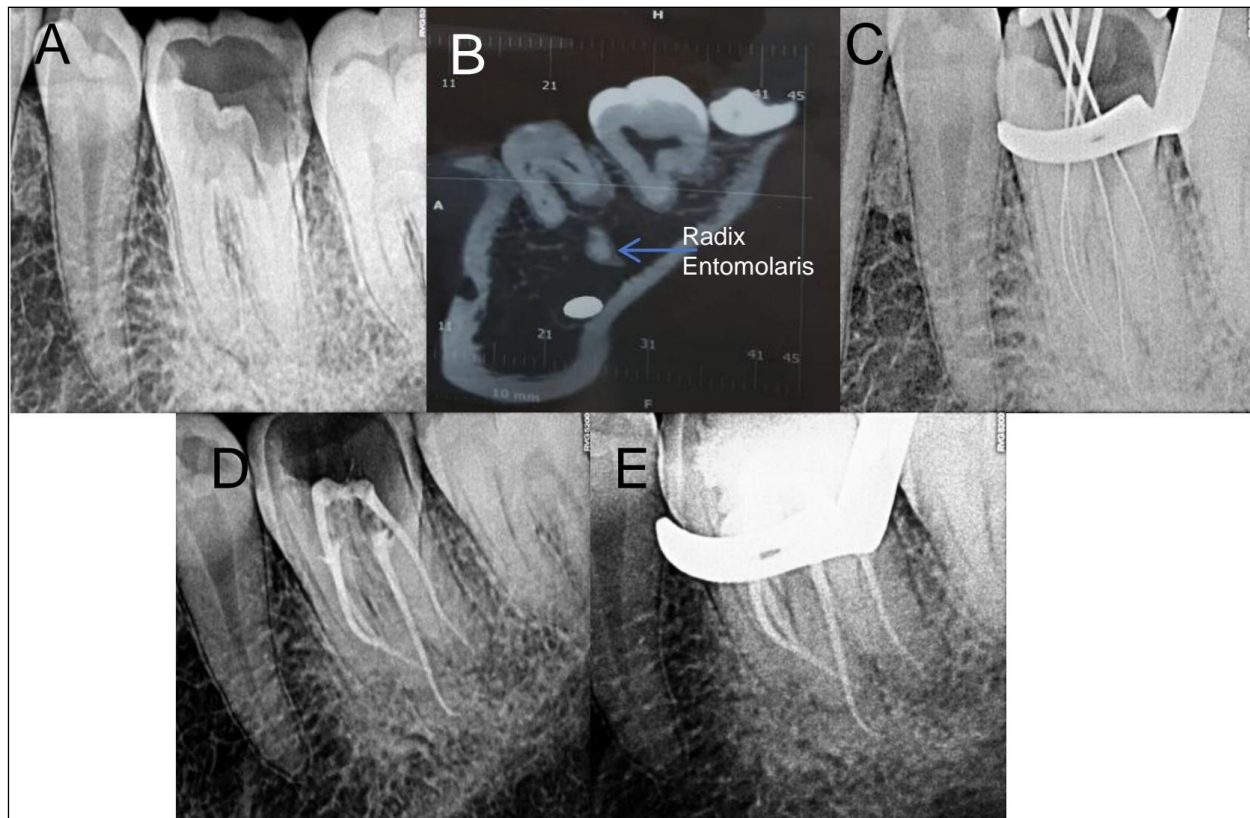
Endodontic Management of the Left Mandibular First Molar (#36) Exhibiting Radix Entomolaris. (A) Preoperative Radiograph. (B) CBCT Image Confirming Radix Entomolaris. (C) Working Length Determination. (D) Obturation Radiograph. (E) Postoperative Radiograph.
